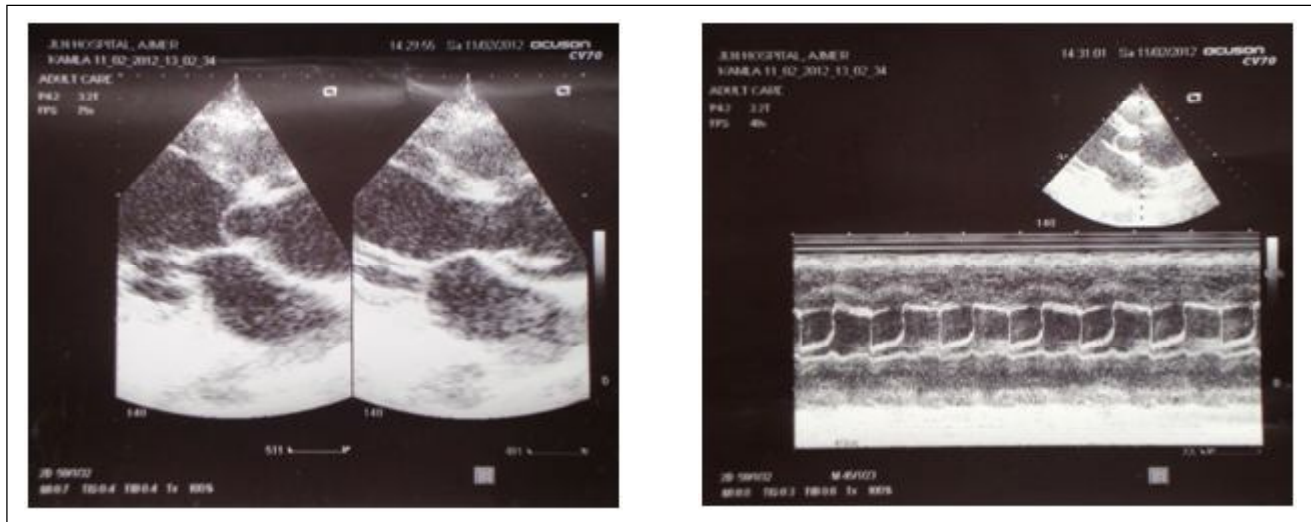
Parasternal long axis view across across aortic valve showing eccentric closure line, M mode tracing at the same level shows rudimentary or absent RCC with prominent excursion of NCC.
